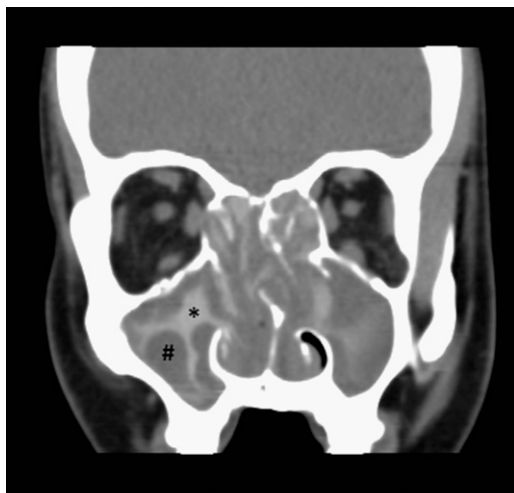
Coronal computed tomography scan demonstrating areas of increased density strongly suggestive of allergic fungal sinusitis. *Indicates hyperdense area; #indicates hypodense area.
